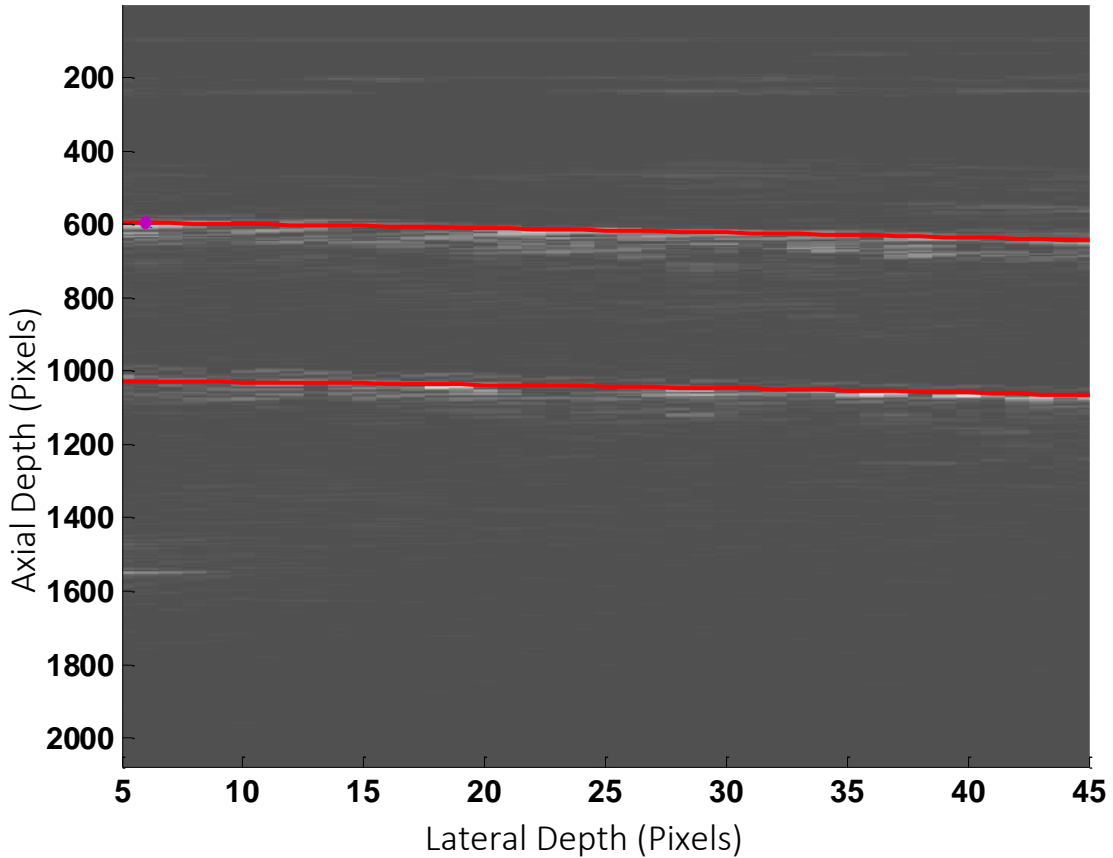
Upper and Lower wall Positions for a single frame (frame 224) of Ultrasound sequence
